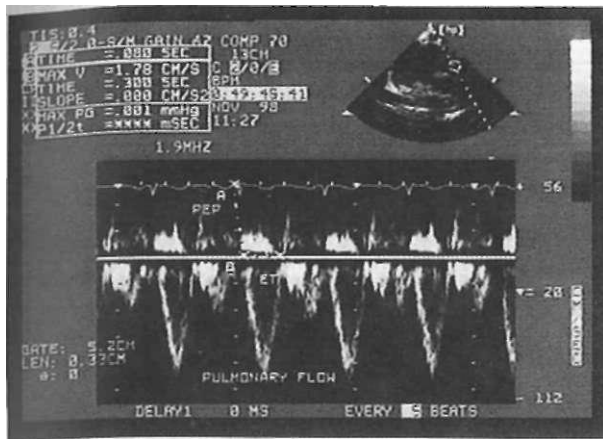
The pulmonary flow from the parasternal short axis echocardiographic view. (PGP: Preejection period, ET: Ejection time)
